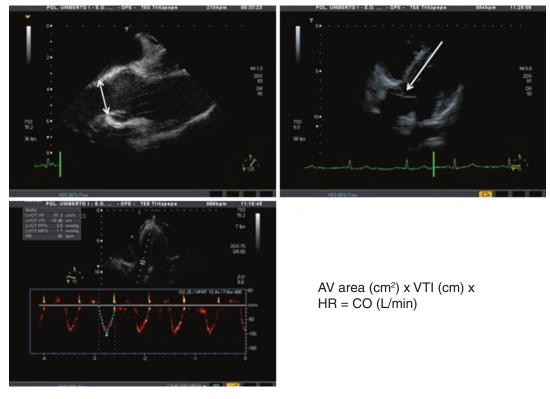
Measurement of CO by measuring the diameter of the aortic outflow tract and the aortic VTI with pulse Doppler
